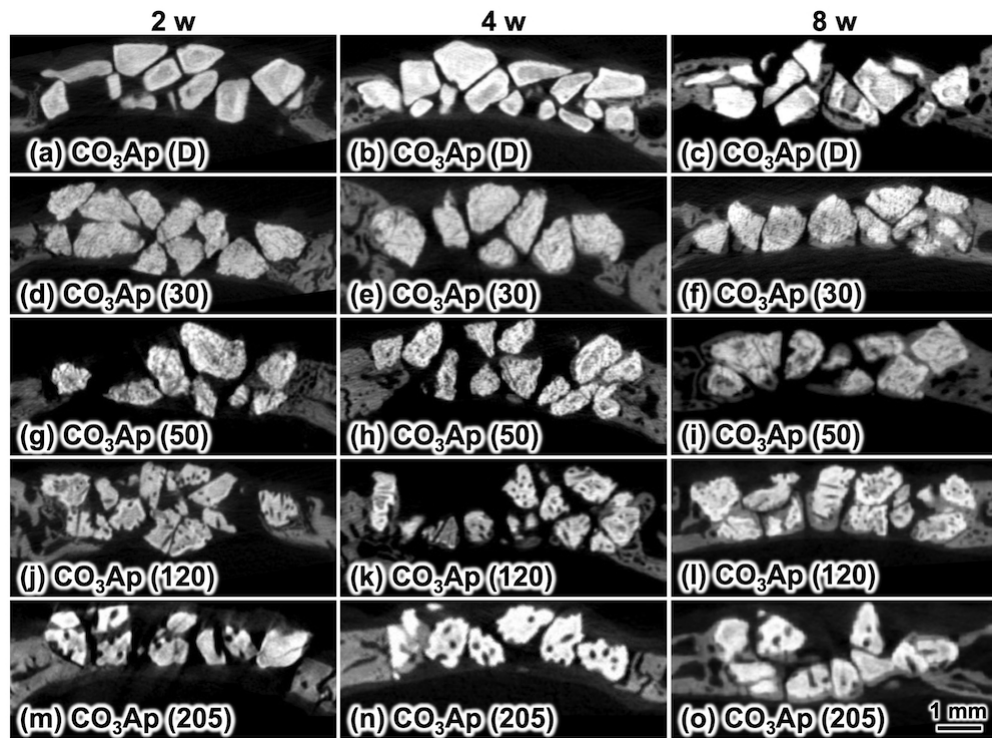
μ -CT images of (a, b, c) CO₃Ap (D), (d, e, f) CO₃Ap (30), (g, h, i) CO₃Ap (50), (j, k, l) CO₃Ap (120), and (m, n, o) CO₃Ap (205) at 2, 4, and 8 weeks after implantation.
